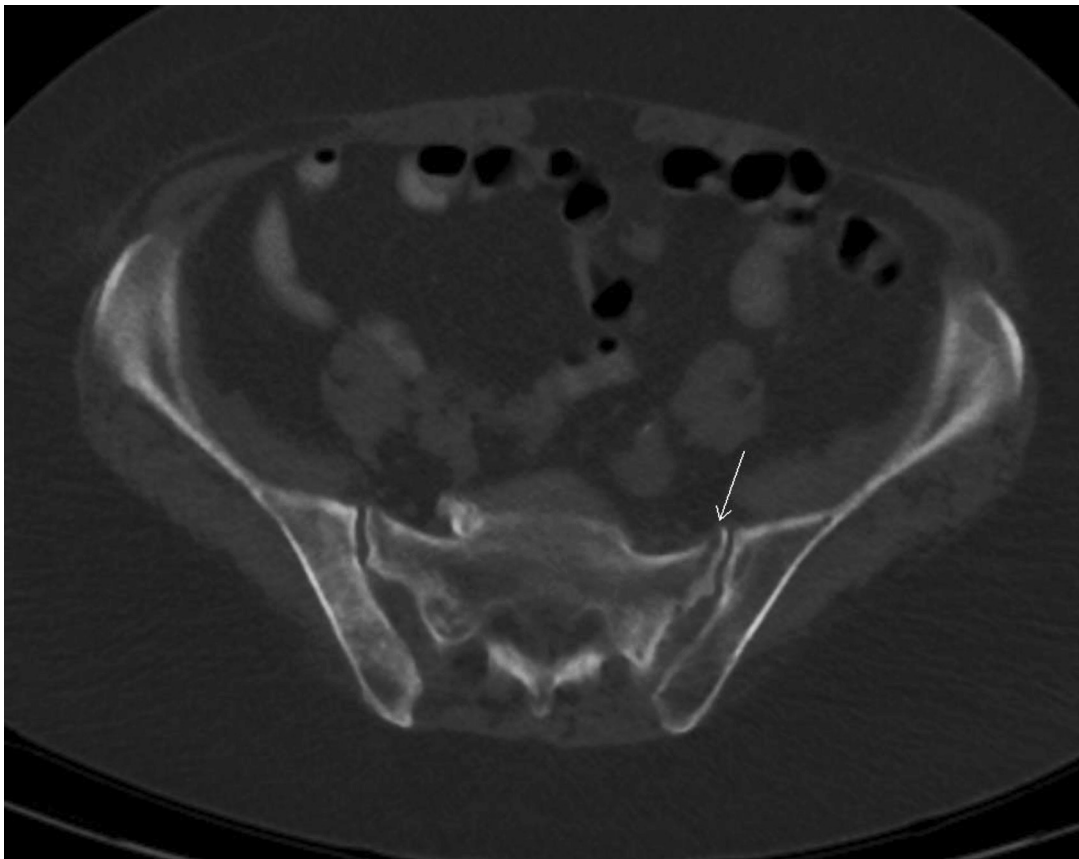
Pelvic computed tomography with the arrow indicating left sacral insufficiency fracture.
